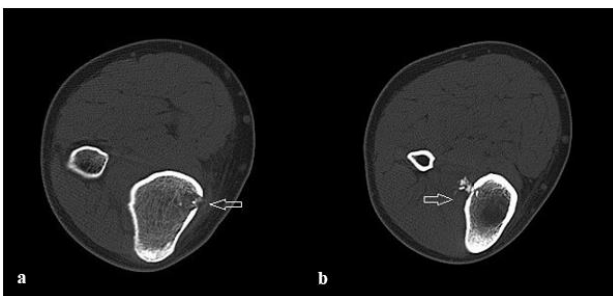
CT images, axial plane: a; inward distortion in the bone cortex in the medial part of tibia due to entry of the bullet core, b; bone fragments concentrated in the lateral part of tibia due to exit of the bullet core
